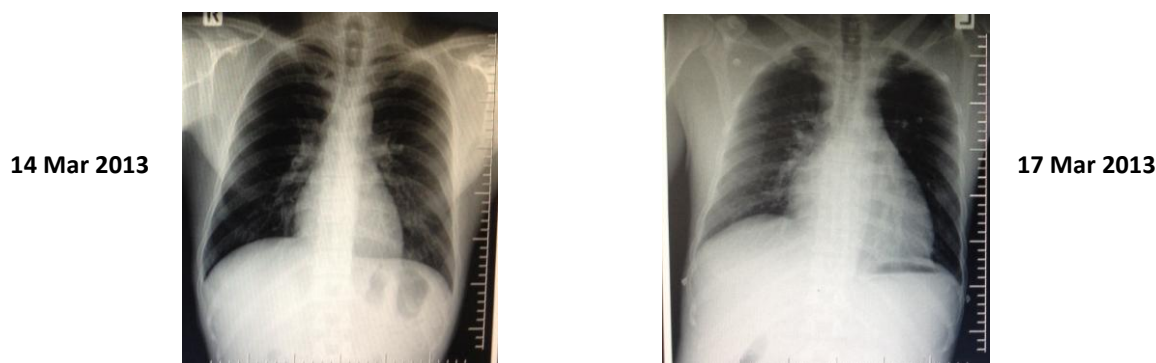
Chest X-rays of a worker with beriberi showing pericardial effusion in Factory A, Thailand, March 2013
